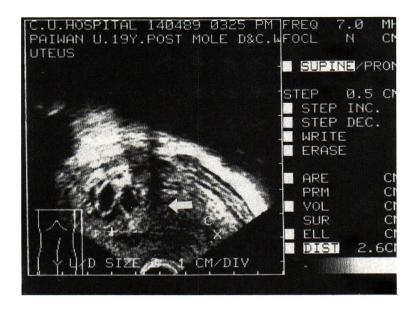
Endovaginal sonography showing coin lesion at uterine fundus.
